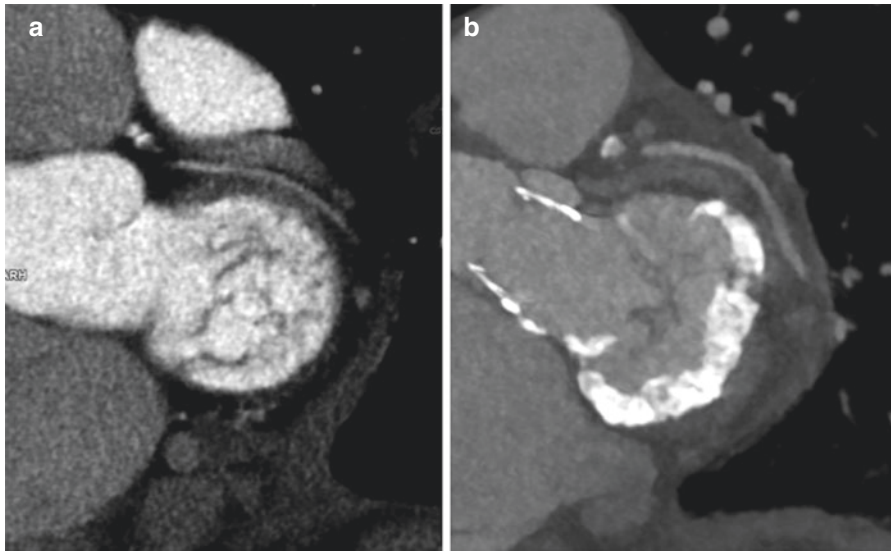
Cardiac computed tomography demonstrating Barlow mitral valve without (left) and with (right) mitral annulus calcification. (Image courtesy of Dr. Jonathan WeirmcCall, Royal Papworth Hospital)
